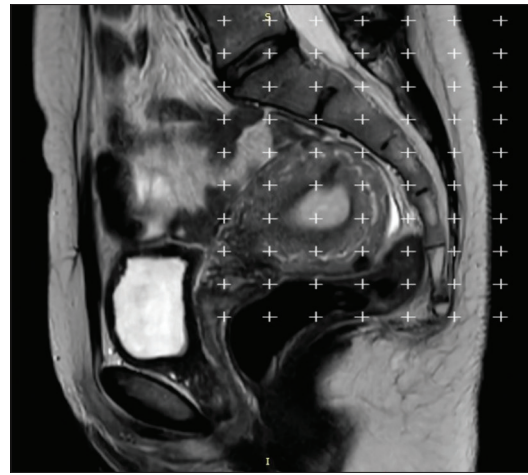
Disposal of the dotted area measurement ruler on the magnetic resonance image
